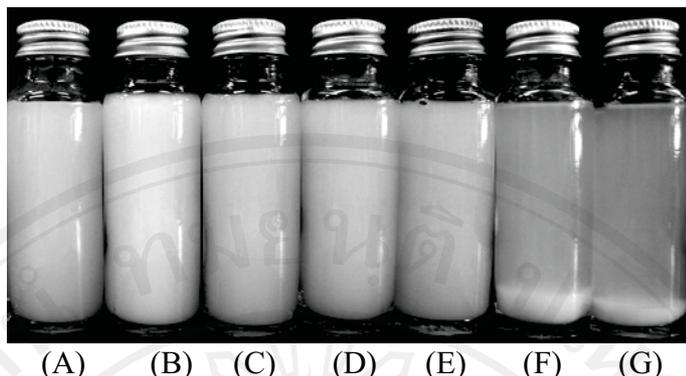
Physical appearances of seven liposomal formulations composing of (A) DPPC/Chol at 7:3, (B) DPPC/Chol/ DDAB at 7:2:1, (C) DPPC/Chol/ CTA at 7:2:1, (D) DPPC/CTA/DDAB at 7:2:1, (E) DPPC/ CTA at 7:3 molar ratio, (F) DPPC/ CTA at 1:1 and (G) DPPC/ CTA at 1:2 molar ratio
